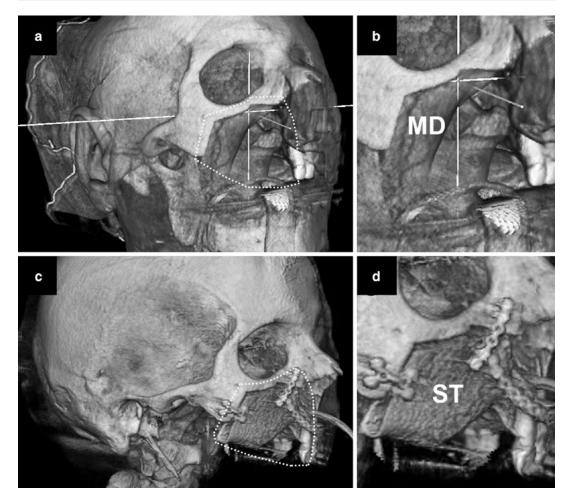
Example of 3D surface rendering from a cone-beam-computed tomography acquired intraoperatively (Guided therapeutics – GTx – operating room, University Health Network, Toronto, Ontario, Canada) (a, b) An infrastructure maxillectomy defect (MD) was carried out and the defect is evaluated and measured to optimize the reconstruction. (c, d): A scapular tip free flap (ST) was utilized for the reconstruction, and an adequate inset ensuring appropriate midfacial projection was
